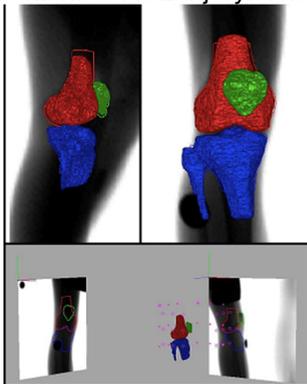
RSA data elaboration: 3D models of bones were obtained from MRI and were used in specific software to reproduce the joint movement through a validated tracking system that matched models and dynamic radiographs.
